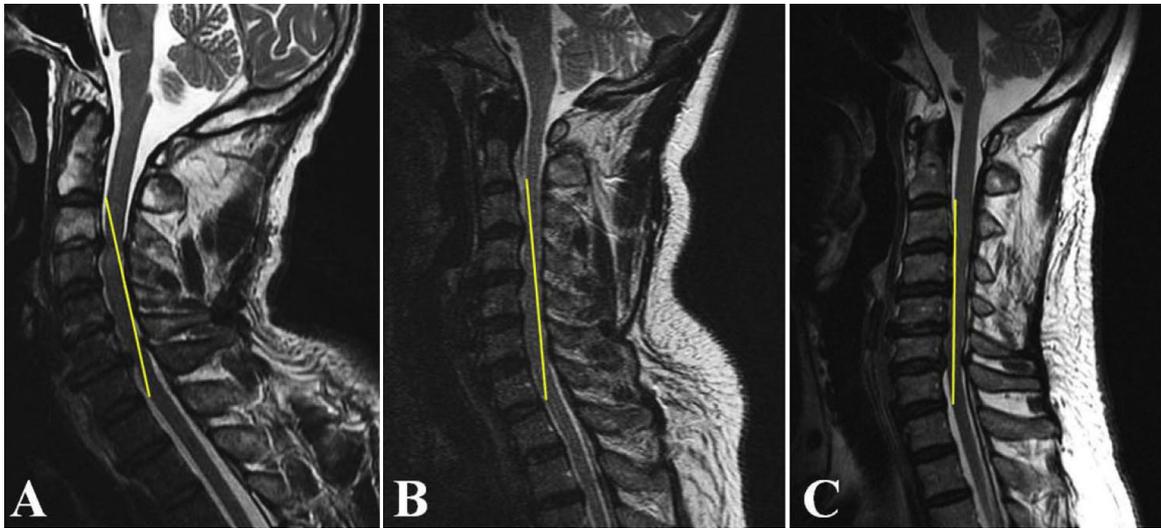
One straight line linking two anterior points of the spinal cord at C2–3 and C7–T1 levels was drawn on T2-weighted images. While this line passed through posterior edge of the spinal cord, within the spinal cord or through anterior edge of the spinal cord, the spinal cord morphology was defined as anterior convexity type (A), neutral type (B), or posterior convexity type (C), respectively.
